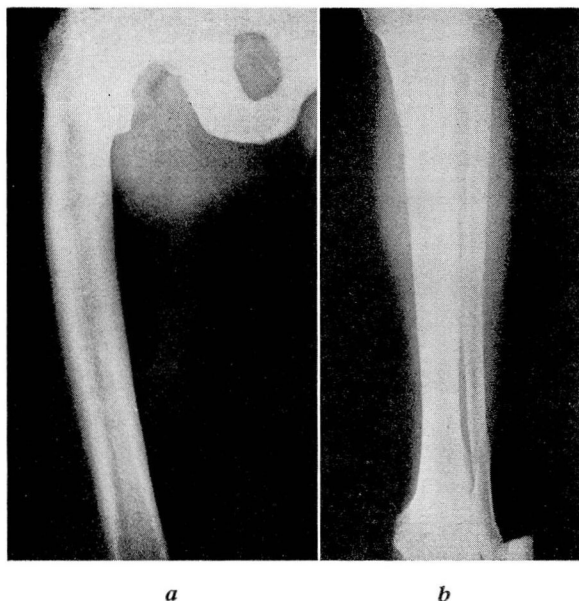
(a) Roentgenogram of the right femur, ischium, and pubis. (b) Roentgenogram of the right tibia and fibula.
